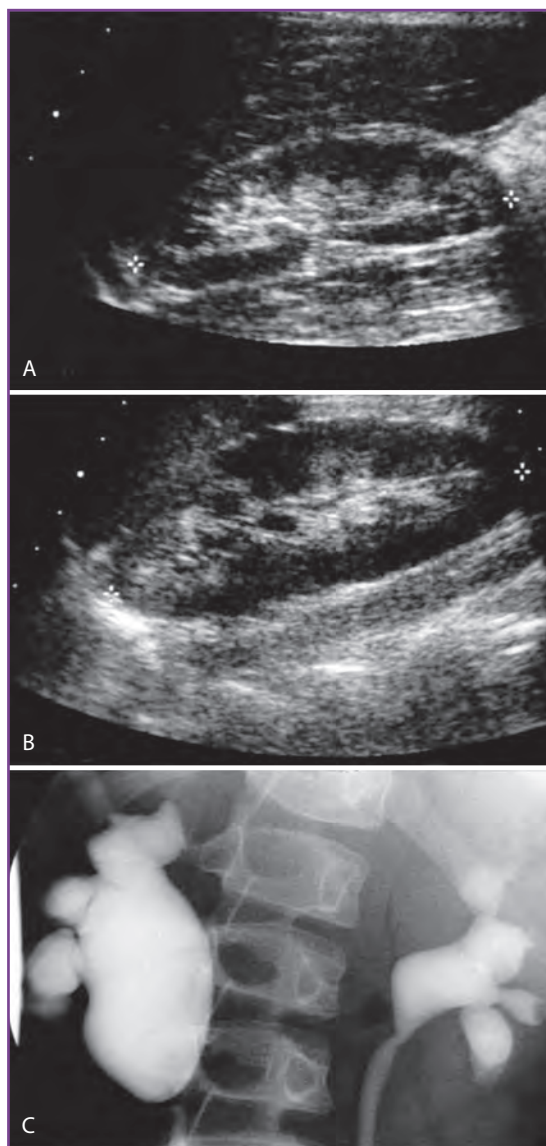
A, B, Normal ultrasonographic findings of the right and left kidneys, despite the presence of high-grade vesicoureteral reflux, as seen with (C) voiding cystourethrography.
